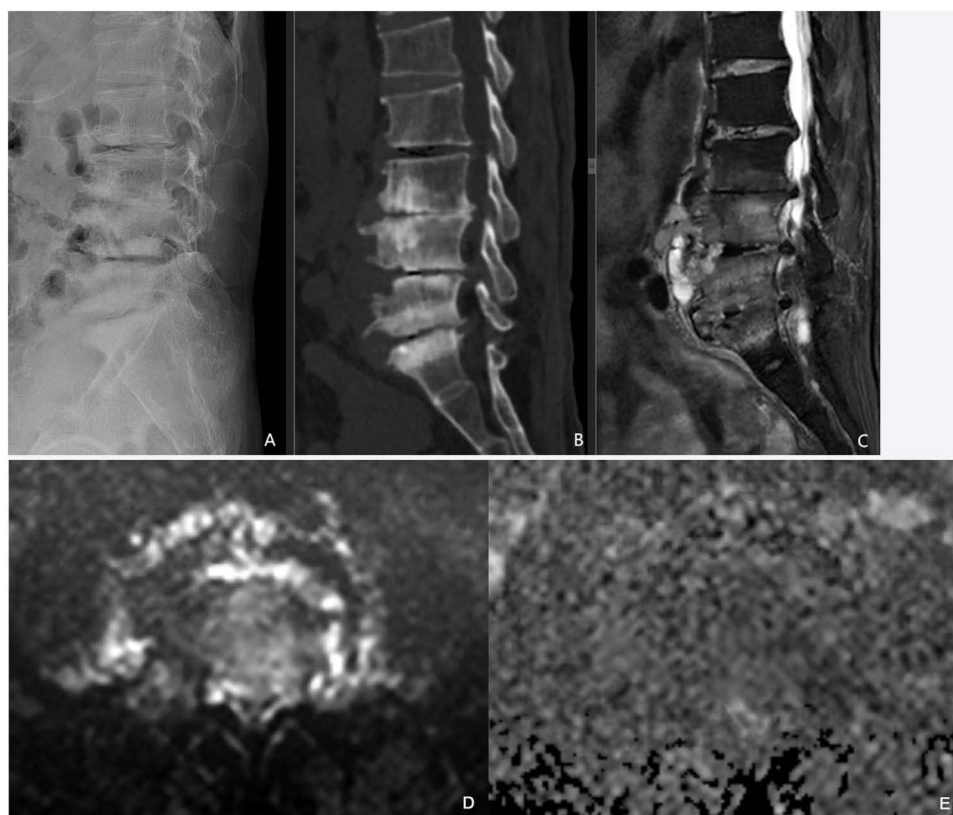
A 58-year-old male was diagnosed with BS in the recovery stage. X-ray diagnosis showed L3-S1 intervertebral space stenosis, and osteosclerosis under the endplate, with no obvious bone destruction (A); sagittal CT scan reconstruction demonstrated L3-S1 intervertebral space stenosis, and worm-eaten bone destruction under the endplate (B); and MRI scan with fat-suppressed T2WI sequence showed slightly high signal granuloma lesions and high signal microabscess under the anterior longitudinal ligament at the level of L3-S1 (C); Axial lumbar DWI (b=600) demonstrated restricted diffusion with hyperintense signal in the paravertebral abscess (D); Axial lumbar ADC map showed hypointense signal in the abscess with restricted diffusion, with ADC values approximately 1.2–1.3 mm²/s (E).
